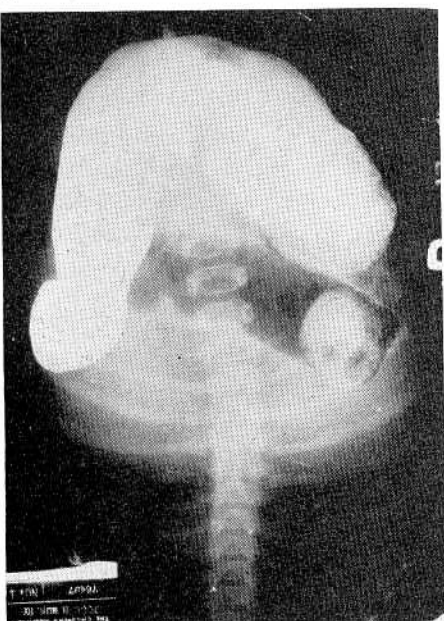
Roentgenogram of patient with rectosigmoid spasm after injection of small amount of contrast media into rectum.
